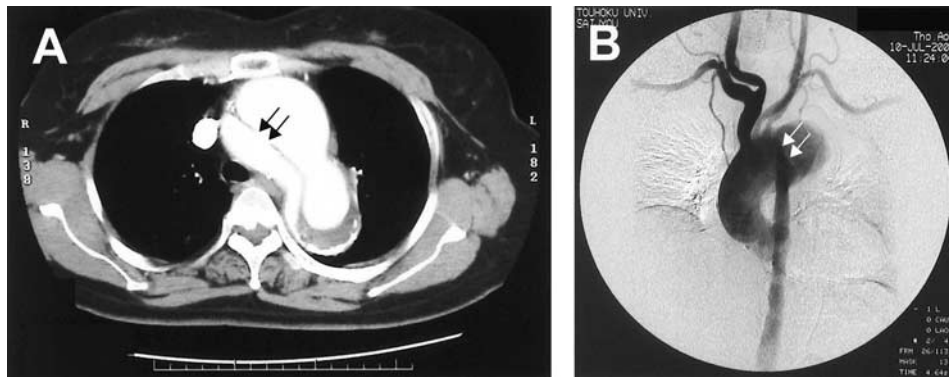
A, Contrast-enhanced computed tomography showing dissecting aortic aneurysm (DeBakey type I, Stanford type A). Arrows indicate proximal (entry) tear of dissection. B, Digital subtraction angiogram showing true and false lumens. Arrows indicate entry.
